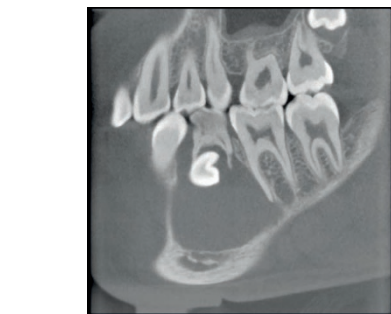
A sagittal section of a CBCT image showing a dentigerous cyst associated with the lower right second premolar
